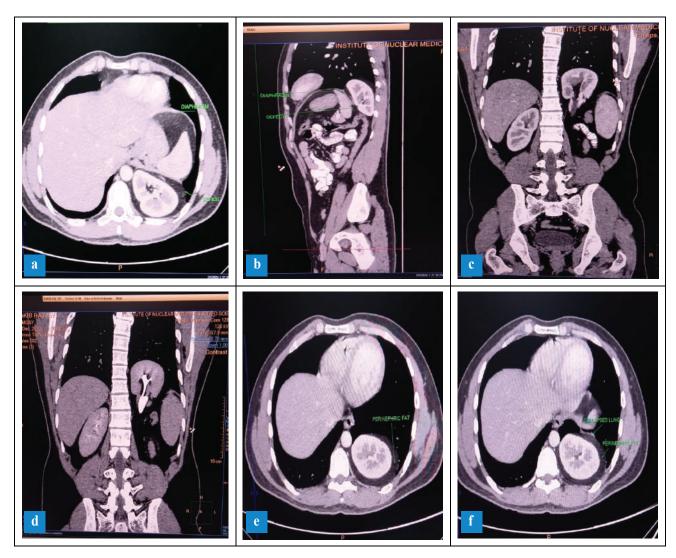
Contrast enhanced CT scan of chest and abdomen in axial and sagittal images showing diaphragmatic defect at postero-medial aspect with herniated left kidney, along with perinephric fat (a,b); coronal images showing diaphragmatic defect with malrotaion of ectopic left kidney with hilum facing antero-infero-medially (c,d) and axial images intrathoracic portion of the left kidney with perinephric fat and deficit of diaphragm, showing small part of collapsed left lung base (e,f).
